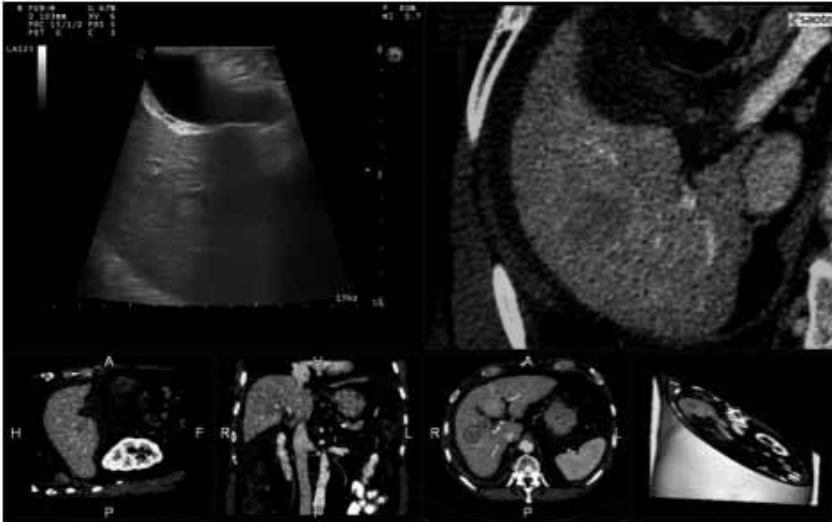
Registration of pre-operative CT-images and intraoperative ultrasound.
